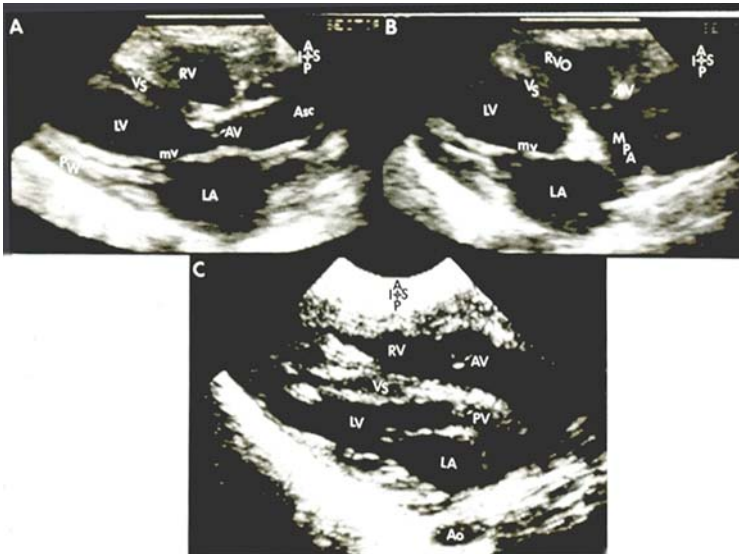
Precordial long axis echocardiographic views of two neonates: first (top, A & B) with normally related great arteries and the second (bottom, C) with transposition of the great arteries. In A, note that the posterior vessel arising from the left ventricle (LV) courses somewhat anteriorly, indicating that it is likely to be the aorta. In B, the anterior vessel coming off the right ventricle (RV) divides into right and left pulmonary arteries, suggesting that this vessel is main pulmonary artery (MPA). In C, the posterior vessel is coursing backward (posteriorly) after its origin from the LV and is likely to be the MPA, suggesting transposition of the great arteries. Ao, aorta; Asc, ascending aorta; AV, aortic valve; LA, left atrium; mv, mitral valve; PV, pulmonary valve; PW, posterior wall of LV; RVO, right ventricular outflow tract; VS, ventricular septum.
